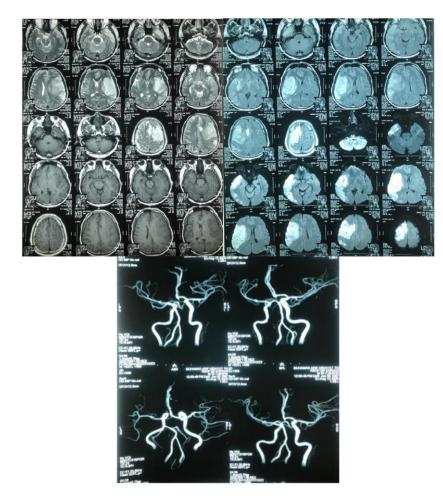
Cerebral MRI, MRA, and MRV
